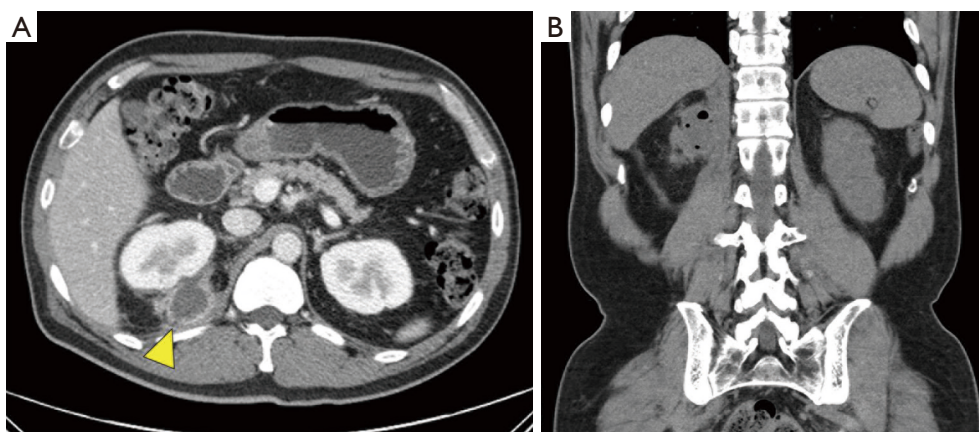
After a total of 4 weeks of antibiotics treatment, follow-up CT scan performed 2 weeks later showed that renal abscess had decreased (yellow arrow) (A). Retroperitoneal emphysema was also decreased (B).
